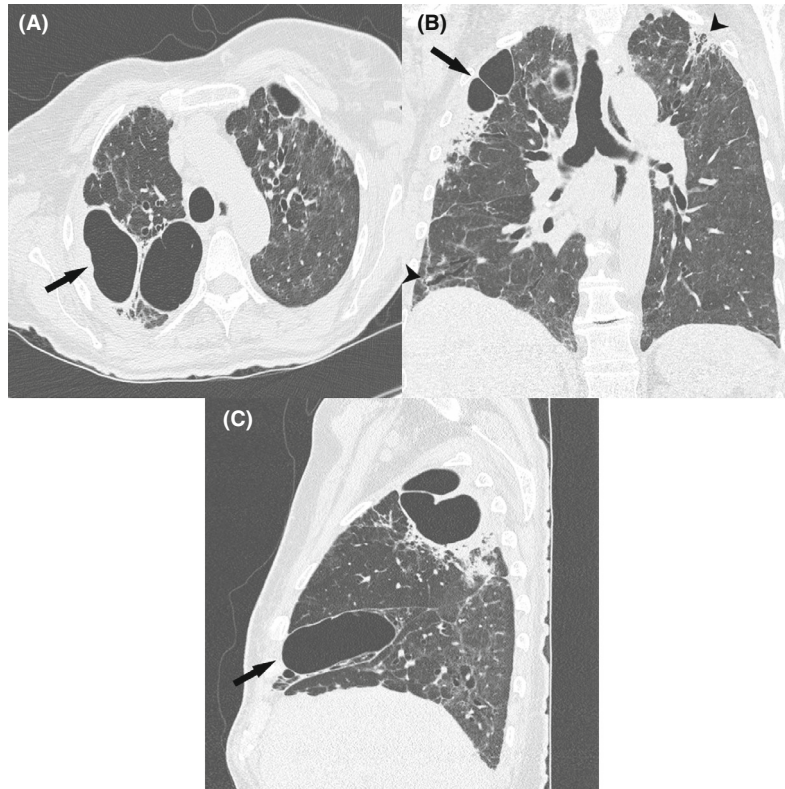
Eight months after discharge. HRCT: Sequelae after COVID-19 infection with pneumoceles (black arrows), cavitating infiltrates and fibrosis like structural changes (black arrowhead). Significant reduction in consolidated areas and only small remnants of ground glass consolidation is seen. (A) Axial lung window, (B) coronal lung window and (C) sagittal lung window.
